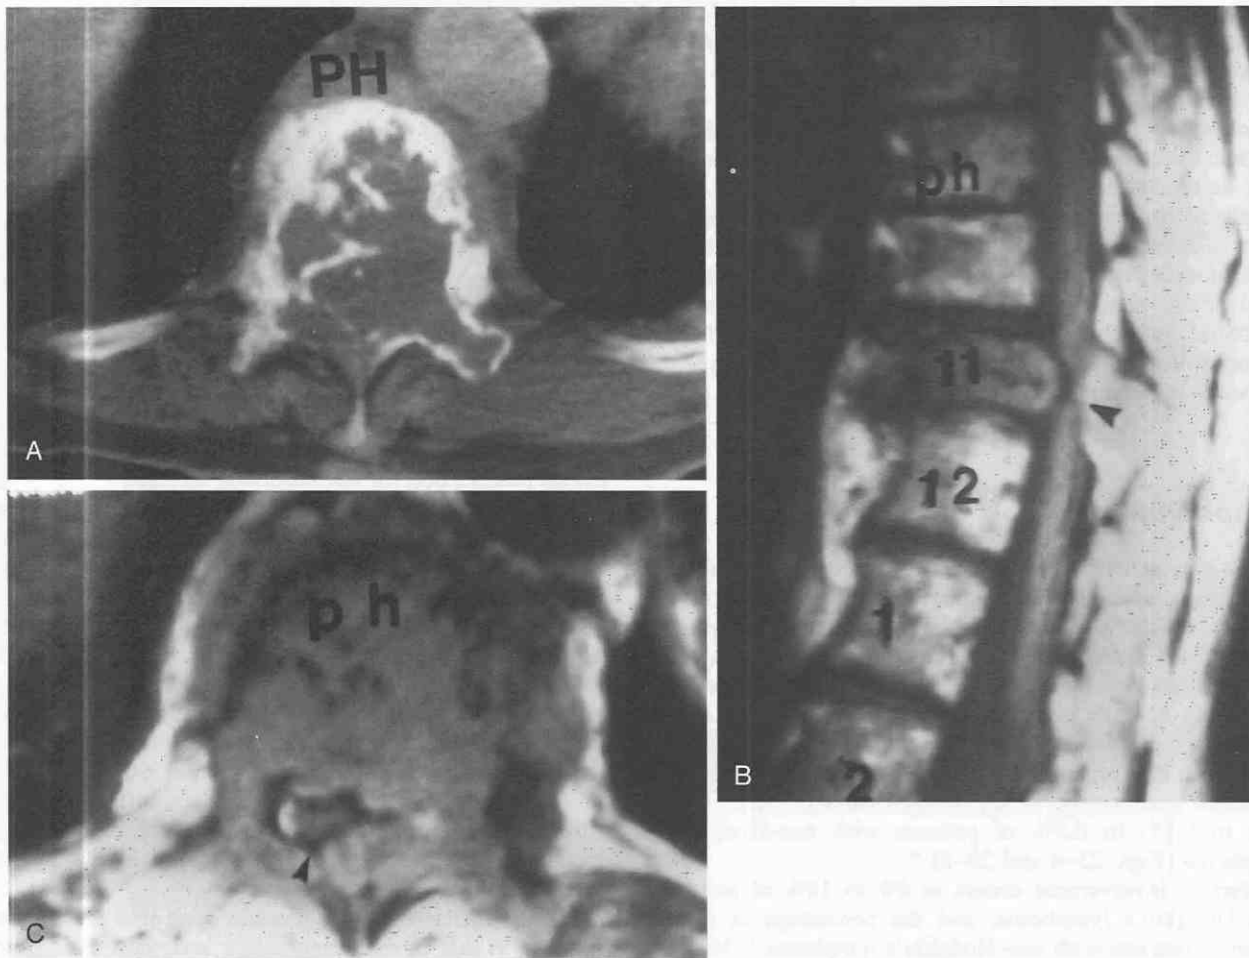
A, Axial CT image through the T11 vertebral body shows a destructive lesion with a soft tissue component, which proved to be multiple myeloma. B, Sagittal T1-weighted image through the lumbar spine shows compression and bone marrow replacement of the T11 vertebral body with associated spinal cord compression. There is also abnormal signal intensity in the surrounding vertebral bodies. C, T1-weighted axial image demonstrating significant spinal cord compression secondary to multiple myeloma mass involving T11. The abnormal signal intensity of the mass is isointense to muscle.
